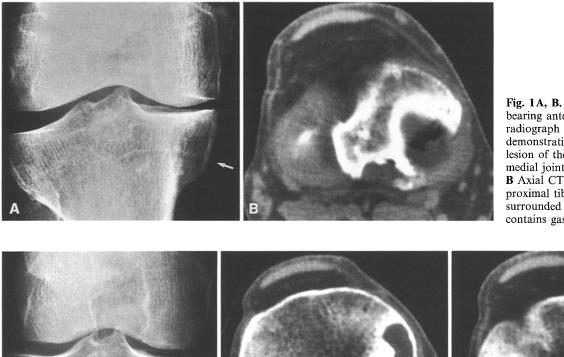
Case 1. A Weightbearing anteroposterior radiograph of the right knee demonstrating a subchondral lesion of the tibia (arrow). The medial joint space is narrowed. B Axial CT through the proximal tibia. The lesion is surrounded by sclerosis and contains gas
